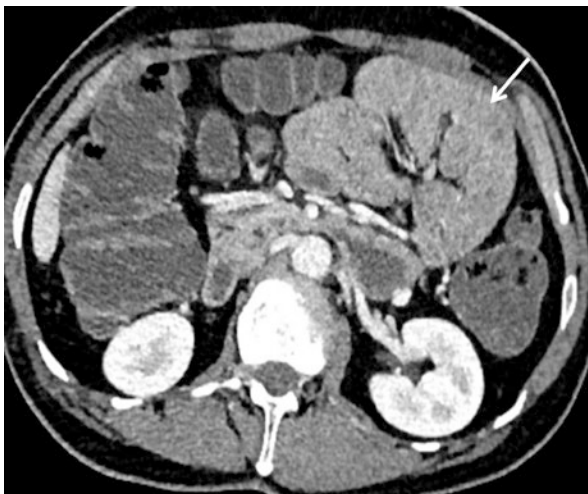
Mesenteric changes in peritoneal tuberculosis. Axial CT scan of lower abdomen shows diffuse thickening of mesenteric leaves (short arrow), mesenteric micronodules (arrow) with ascites and smooth thin peritoneal thickening (thick arrow). A combination of findings is often present in a single patient which aids in diagnosis
